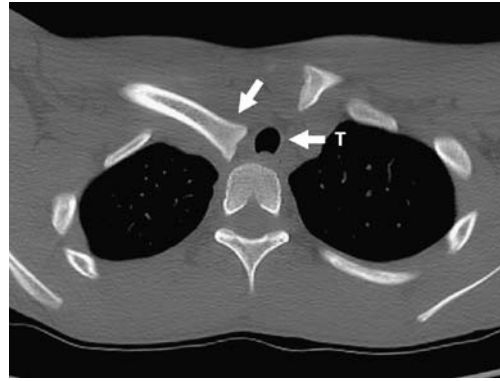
Axial CT view. Note the posteriorly displaced right clavicle (*arrow*) causing some displacement and encroachment on the trachea (*arrow T*)
